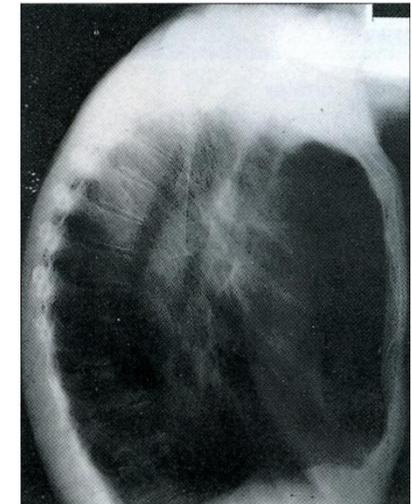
Emphysema. The right lateral chest X-ray shows hyperinflation of the chest with sparse lung markings. There is a marked increase in the posteroanterior diameter of the chest, and the diaphragmatic depression is again seen. In this patient the hilar calcification resulting from old, healed tuberculosis is also well seen in the lateral view.
